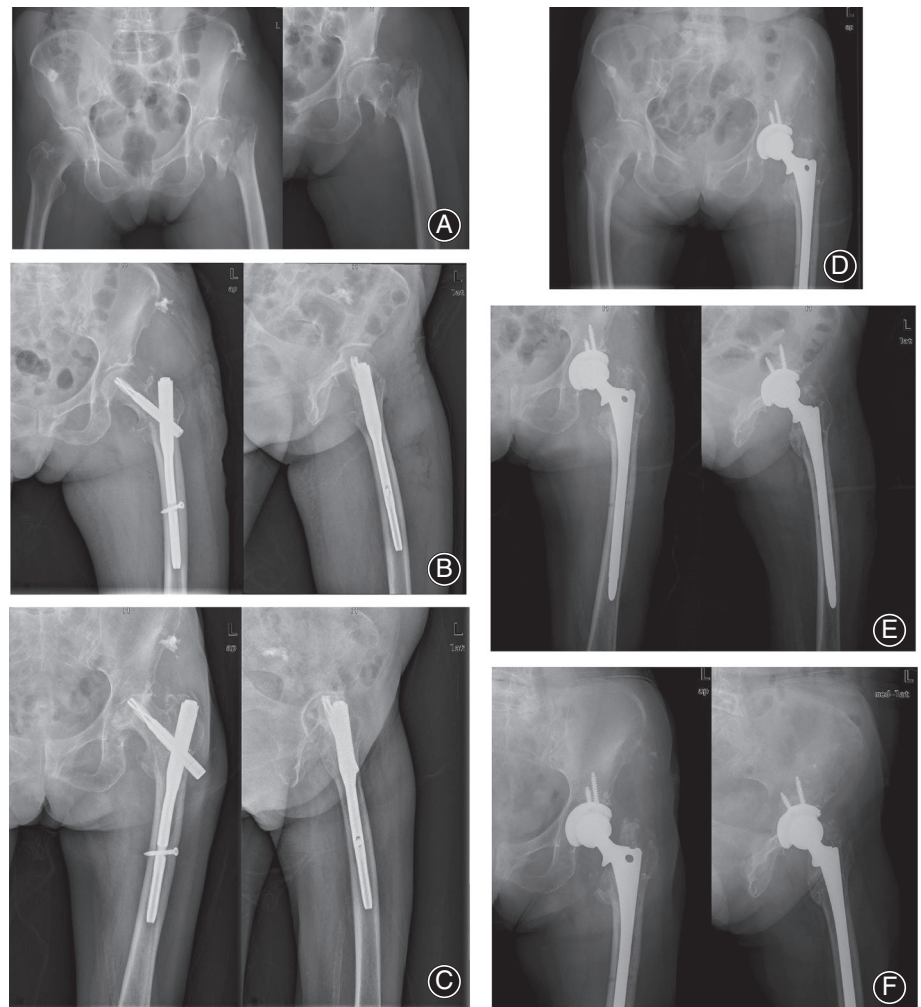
A 76-year-old female patient with initial left intertrochanteric fracture (type A2) 14 months after fixation with proximal femur nail anti-rotation (PFNA) accepted total hip arthroplasty (THA) for initial fixation failure. (A) Preoperative anteroposterior X-rays of pelvic and injured hip. (B) Anteroposterior and lateral X-rays at immediate after the internal fixation of PFNA. (C) Anteroposterior and lateral X-rays at 14 months after fixation of PFNA, showed femoral head necrosis. (D) Anteroposterior X-ray of pelvic at immediate after THA. (E) Anteroposterior and lateral X-rays of the hip at immediate after THA. (F) Anteroposterior and lateral X-ray films of the hip at 3 months after THA.
